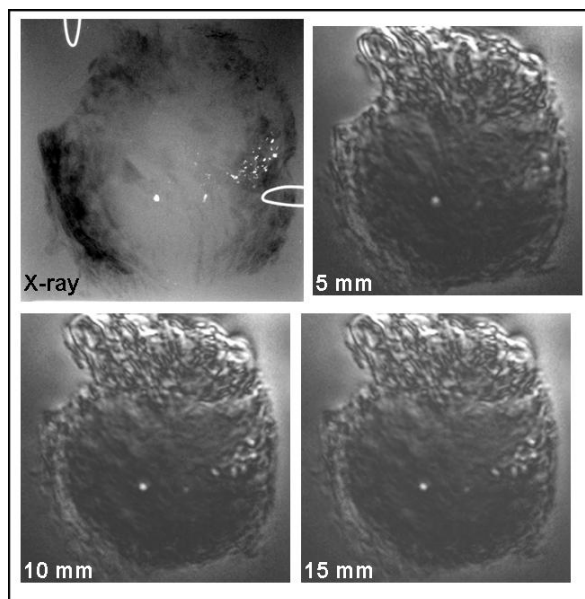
X-ray and VA images acquired at different depths are shown. Calcifications are clearly seen at all depths in VA, especially at 10 and 15 mm, as confirmed by X-ray.
